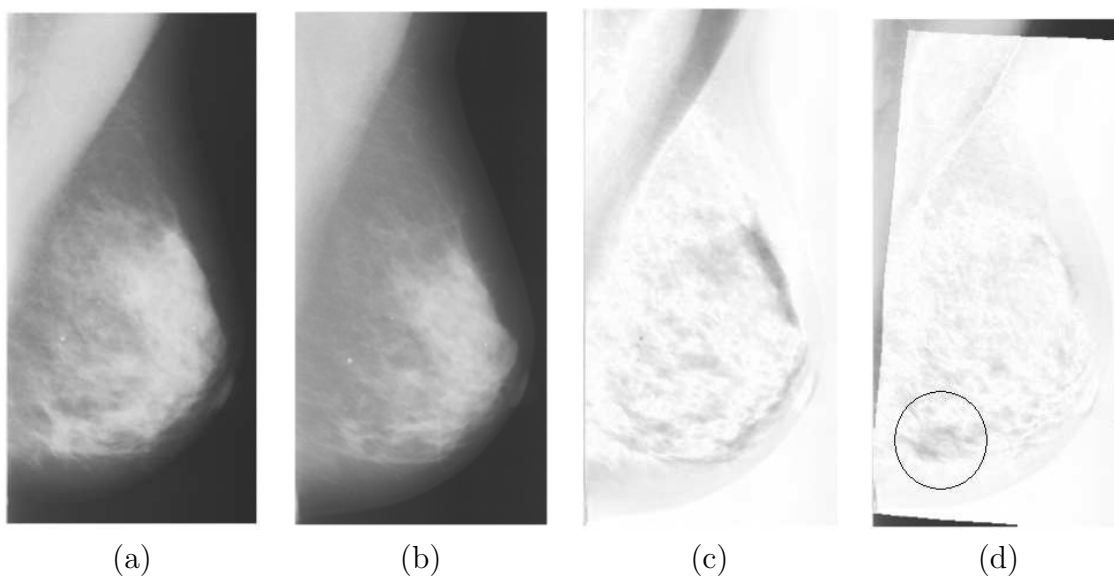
Sample of temporal study with X-ray mammography, where (a) is the current mammogram and (b) previous mammogram. The direct intensity difference (c) of the pair of mammograms does not reveal the real changes, while the registered one (d) does, as denoted by the black circle.
